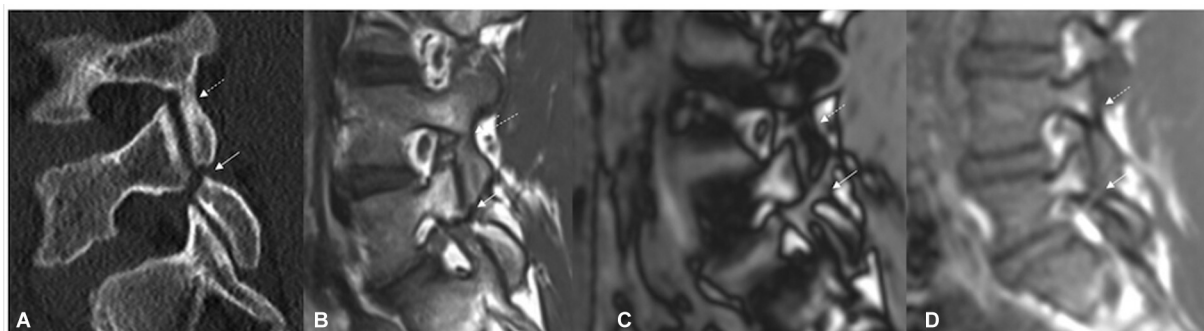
Sagittal computed tomography (A), T1 (B), chemical shift out phase (C) and in phase (D) showing pars defect of L5 (arrow) and intact pars of L4 (dashed arrow).
